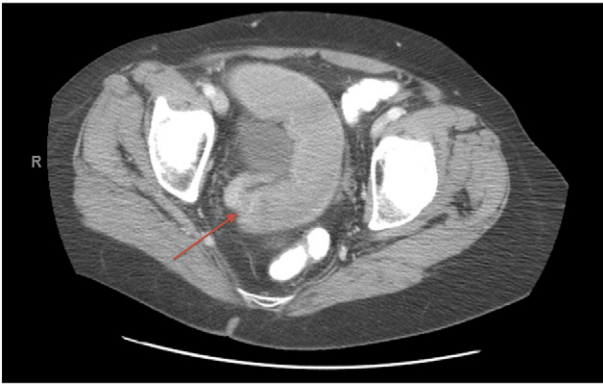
Computed tomography image of a single site of small bowel obstruction.
